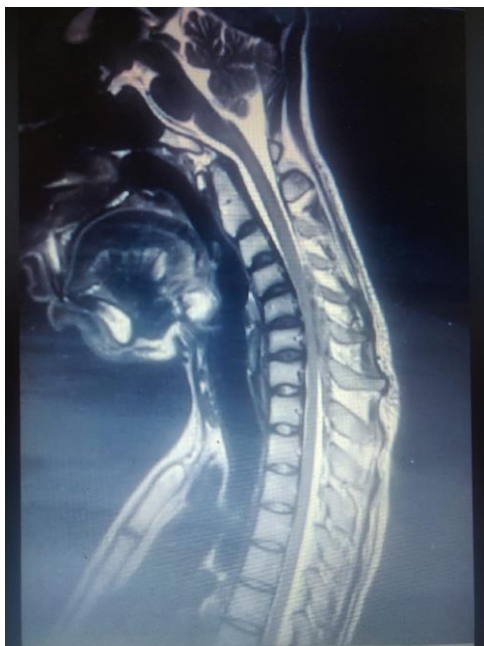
MRI cervical spine – flexion view
